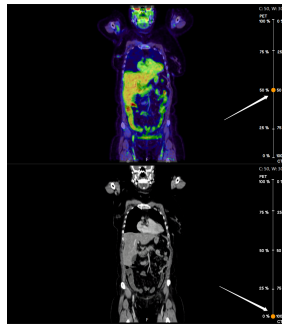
Presentation of a PET/CT image being changed from being 100 % CT, the bottom image, to 50 % PET and 50 % CT, the top image, with the selected percentage visualized to the right.
